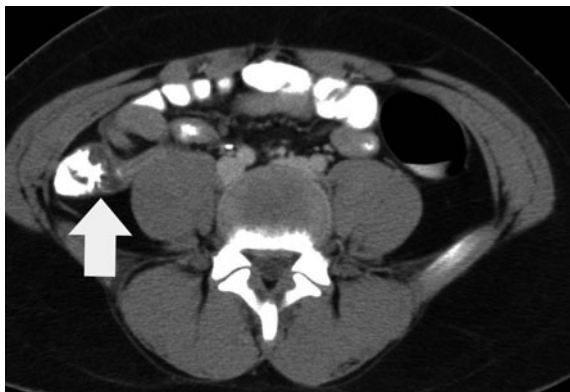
Appendicitis in a 12-year-old-male with abdominal pain. Axial contrast-enhanced CT shows the arrowhead sign formed by inflammation at the base of the appendicitis. Note that the *arrowhead* points to the base of the appendix
